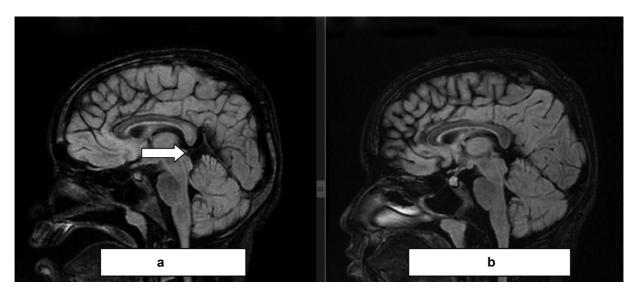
(a, b) Fluid-attenuated inversion recovery image in initial magnetic resonance imaging shows hyperintensity in the splenium of corpus callosum, which appears to be resolved in the follow-up scan.
